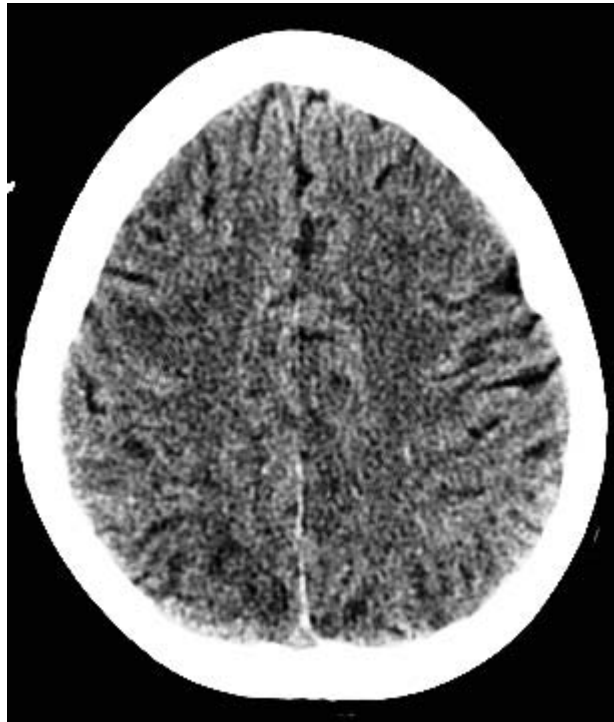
Axial brain non-enhanced CT image showing multiple right frontal and right parietal subcortical hypodensities
